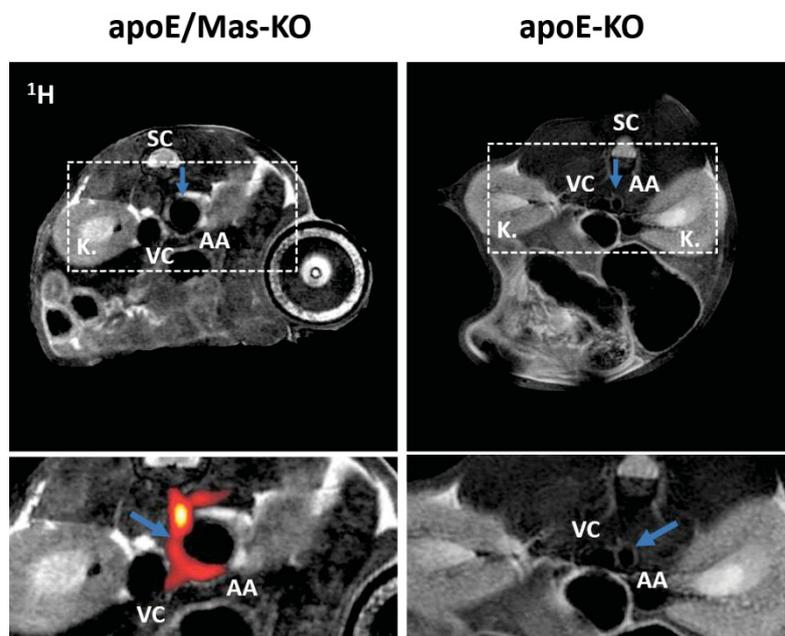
$^1\text{H}/^{19}\text{F}$ MRI measured abdominal images.
